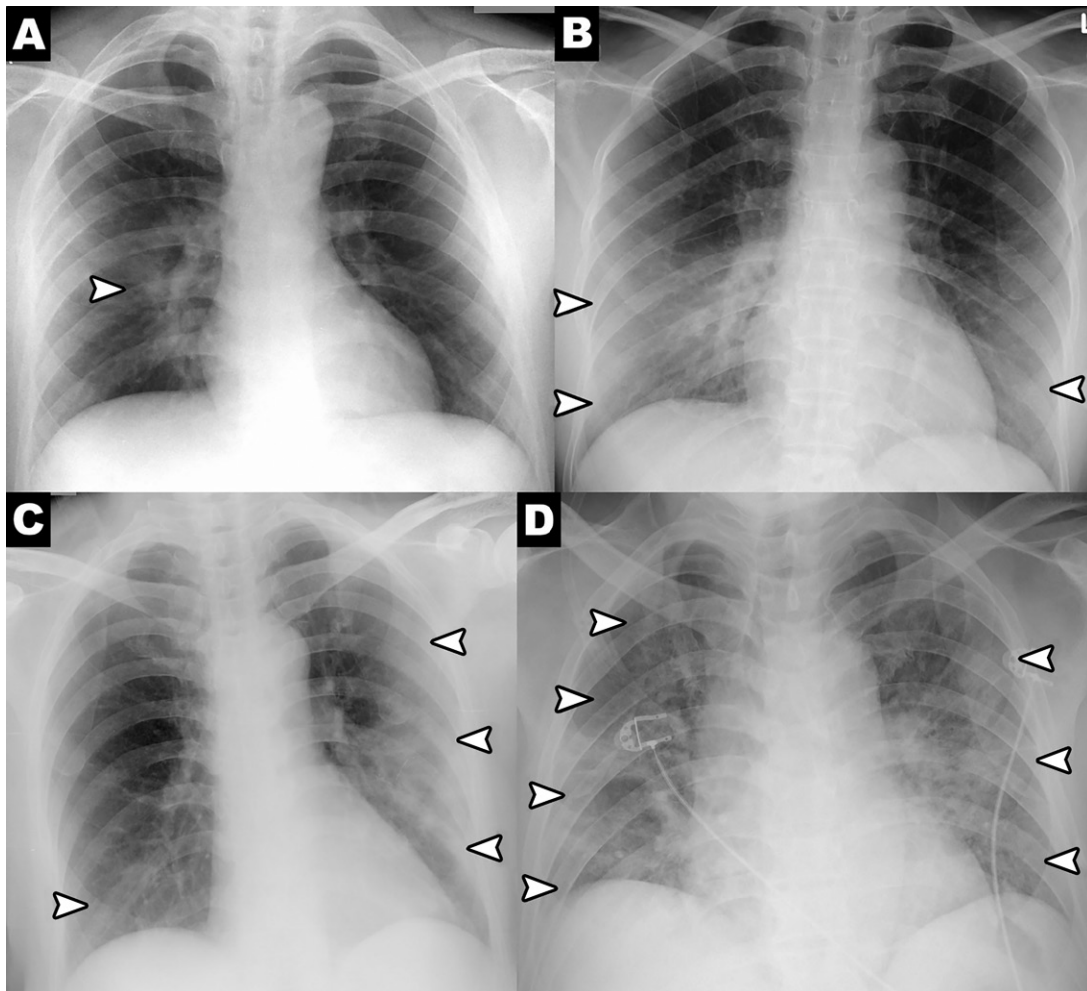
Chest radiography scoring system. A score of 0–4 was assigned to each lung depending on the extent of involvement by consolidation or ground-glass opacities (0, no involvement; 1, <25%; 2, 25%–50%; 3, 50%–75%; and 4, >75% involvement). The scores for each lung were summed to produce the final severity score. Examples of chest radiography severity scoring in patients with coronavirus disease 2019 and days from symptom onset are shown as follows (the calculation right lung score + left lung score = total score was used): A, day 12 (1 + 0 = 1); B, day 5 (2 + 1 = 3); C, day 3 (1 + 3 = 4); and, D, day 10 (4 + 3 = 7). Arrowheads indicate areas of consolidation or ground glass.
